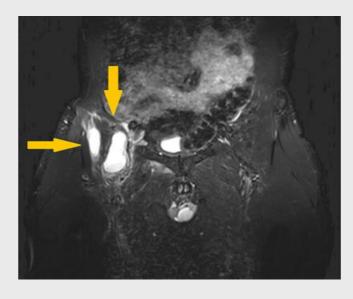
T1-weighted magnetic resonance imaging coronal plane of the pelvis. The image shows a pathologically increased liquid concentration and bone edema around the right hip joint (left).
